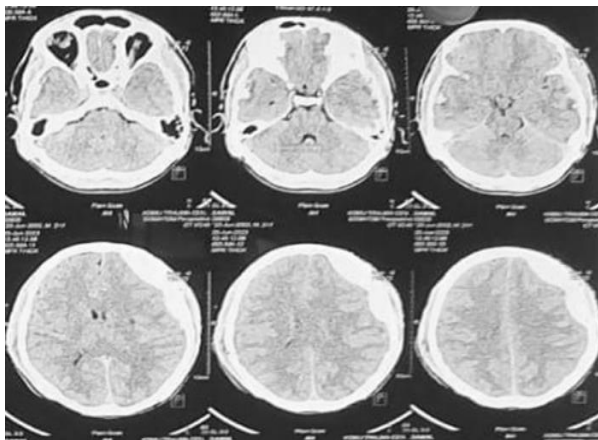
CT scan showing left fronto parietal SDH with right temporal contusion.
